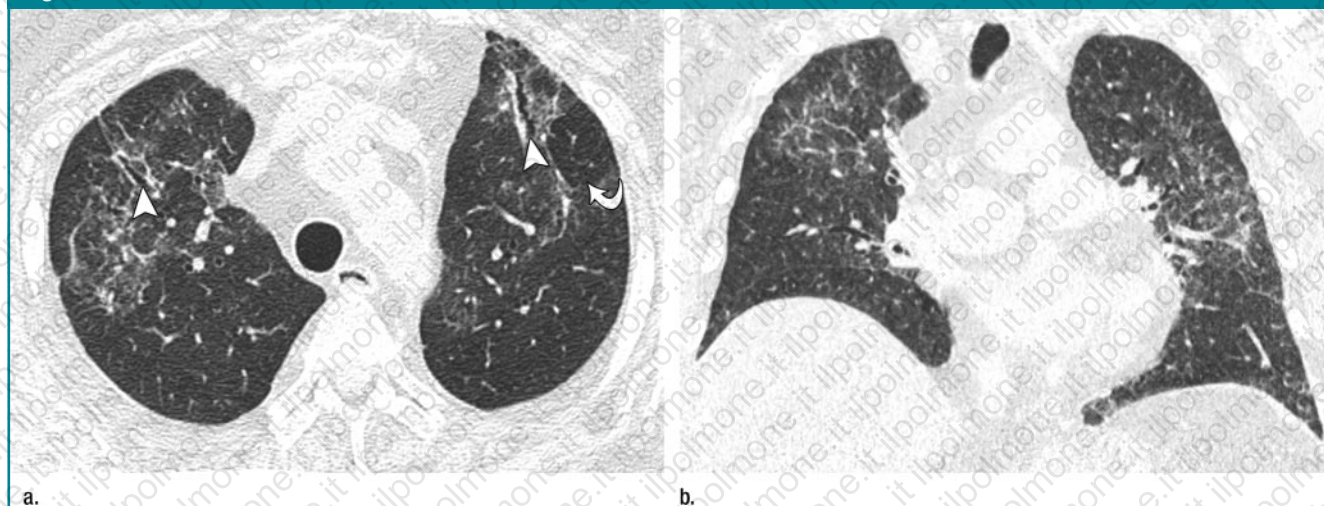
Chronic HP in 72-year-old man exposed to birds. (a) Transverse thin-section CT scan of upper lobes shows patchy GGO and superimposed reticulation in predominant peribronchovascular distribution. Note bronchial tortuosity and irregularity (traction bronchiectasis, arrowheads) due to fibrosis and peripheral lobule (arrow) with decreased attenuation and vascularity in left upper lobe. (b) Coronal reformation shows predominant distribution of abnormalities in upper lobes.
